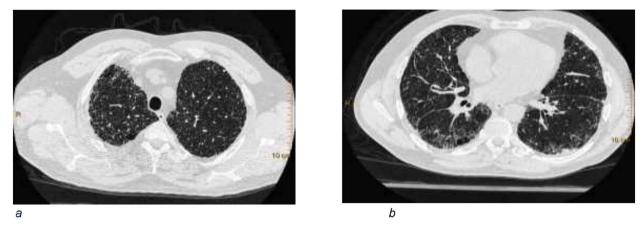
4a: Inspiratory HRCT images of the upper lobe showing cysts and fine reticulation.4b: Inspiratory HRCT images of the lower lobe showing fine reticulation, cysts and traction bronchiectasis.
